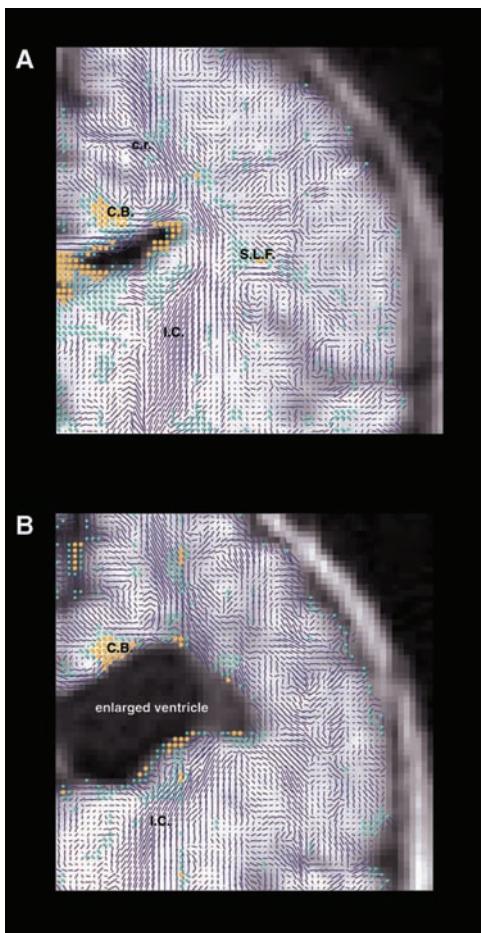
Diffusion vector maps were overlaid on coronal diffusion-weighted MRI scans; yellow dots represent higher relative anisotropy values than green dots. The images show a premature infant at term (A) without perinatal white matter injury in and (B) with perinatal white matter injury in. The posterior limb of the internal capsule in (A) shows more homologous-directed vectors that are longer and more densely packed than in the internal capsule of (B). Anteroposterior-oriented WM fibers in the area of the superior longitudinal fasciculus in (A) indicate the presence of fiber bundles that are missing or less prominent in (B). Fibers in the corona radiata appear better organized in (A) than in (B). Abbreviation: MRI, magnetic resonance imaging.
